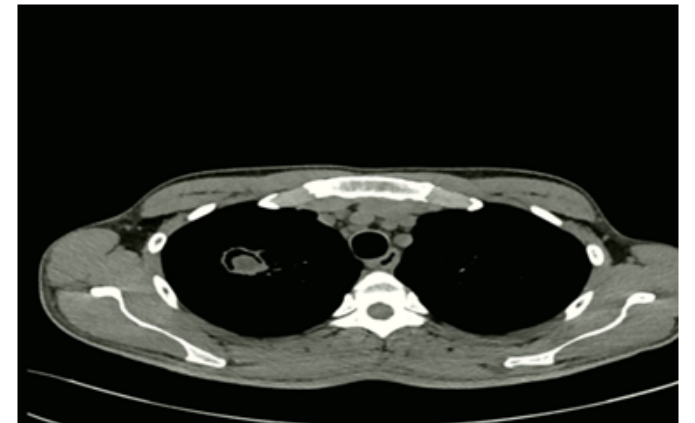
CT chest showed cavitary mass lesion in the apical segment of the right upper lobe with thin irregular wall surrounded with air known as air crescent sign.
